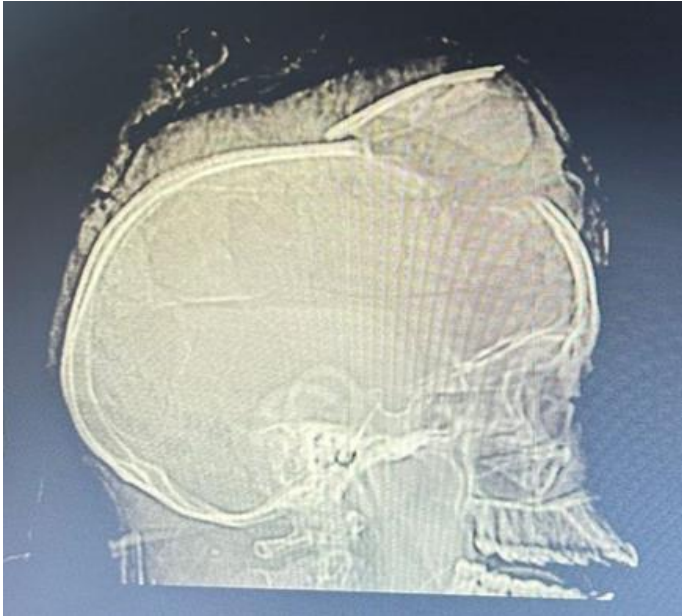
Pre-operative CT scan image showing lacerated wound exposing frontal lobe
